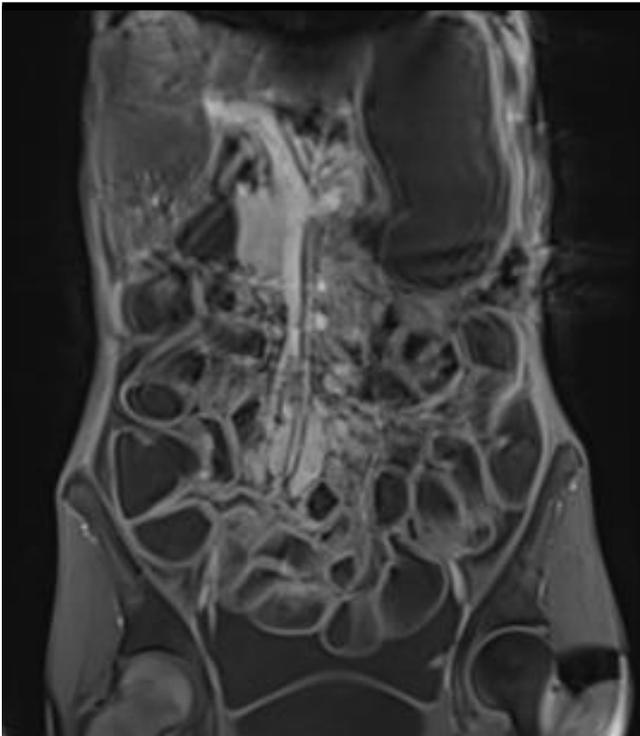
Abdominal MRI showed dilated ileal and jejunal loops and diffuse ascites in the abdomen.
